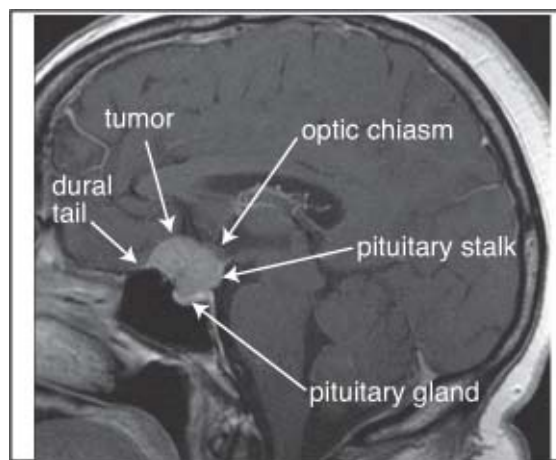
Tuberculum sellae meningioma that could be mistaken for a pituitary adenoma. Contrast enhanced T1WI sagittal MRI
